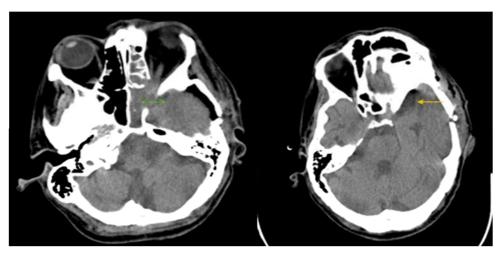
Rt: Evidence of the abscess removal in post-op brain CT imaging (yellow flash), Lt: the route between the sphenoid and posterior ethmoidal sinuses due to the fungal invasion (green flash)
